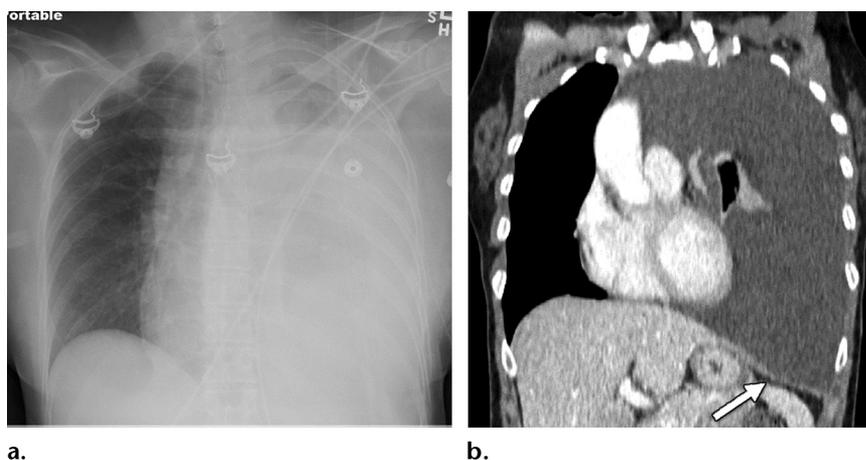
Chylothorax in a patient with chronic dyspnea 6 months after left-sided thoracic outlet decompression surgery. Postoperative radiography showed normal findings (not shown). Chest radiograph (a) and coronal CT image (b) show a large left pleural effusion. The pleural fluid was simple but exerted tension, displacing the mediastinum to the right and inverting the left hemidiaphragm (arrow in b). Chylous fluid was drained from the pleural fluid collection. Initial management consisted of diet modification and octreotide, but medical management ultimately failed and surgical thoracic duct ligation was necessary.
